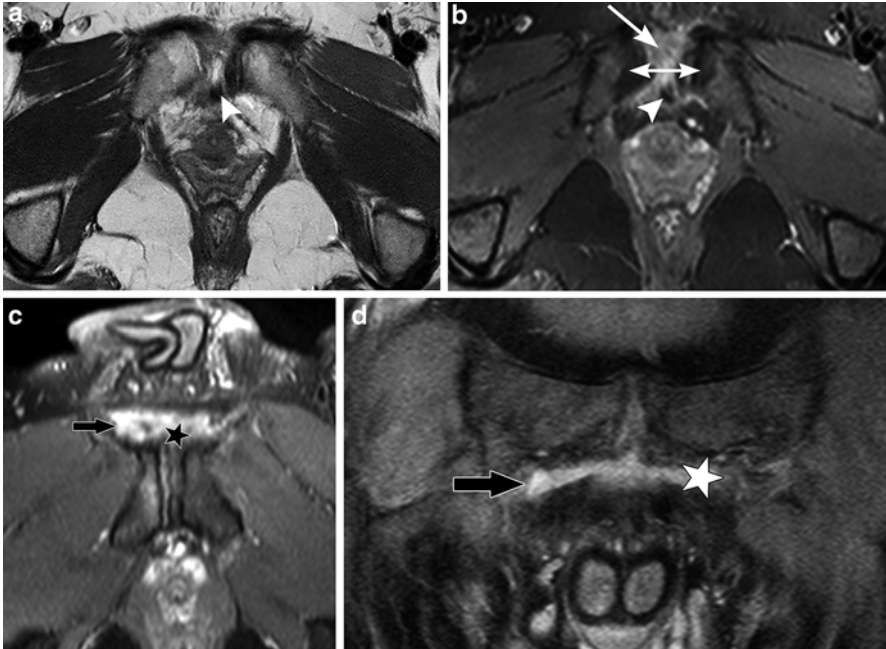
Comparison of pubic symphysis capsular injuries seen postpartum (a, b) with chronic exertional groin pain (c, d). A 29-year-old woman, 3 months postpartum vacuum-assisted vaginal delivery presenting with pelvic girdle pain syndrome and known pubic diastasis, same patient as in Fig. 3.1. MRI imaging of the pubic symphysis and pelvic floor with (a) axial T1 sequence and (b) axial T2 fat saturation demonstrate diastasis of the pubic symphysis (*double headed arrow*) with posterior displacement of the central fibrocartilaginous disc (*arrowhead*) and fluid present within the disrupted symphysis (*arrow*). There are no tears of the muscle insertions. A 28-year-old male soccer player and long distance runner presents with pubic symphysis injuries and a normal pelvic radiography. MRI imaging of the pubic symphysis with (c) axial T2 fat saturation sequence and (d) coronal T2 fat saturated sequence demonstrate right adductor insertional tendon injury (*black arrow*) and tear of the combined aponeurosis of the rectus abdominis tendon, adductor tendon, and anterior pubic symphysis capsule (*star*)
